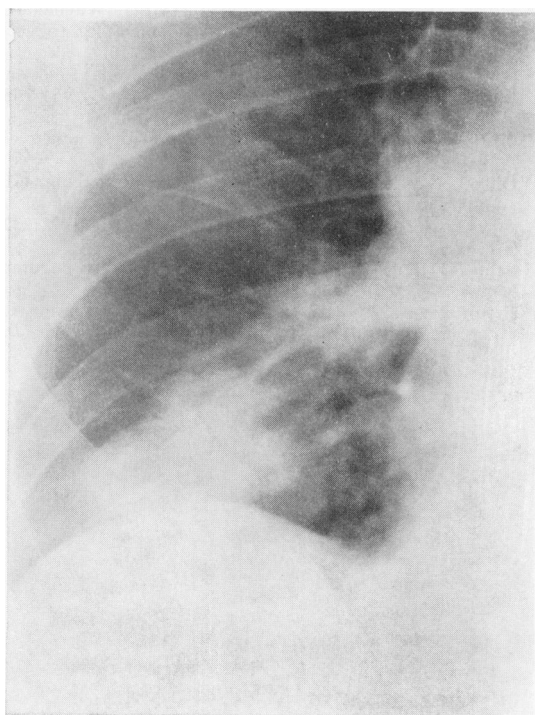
Close-up of admission chest radiograph showing nodular densities over right middle and lower zones.
